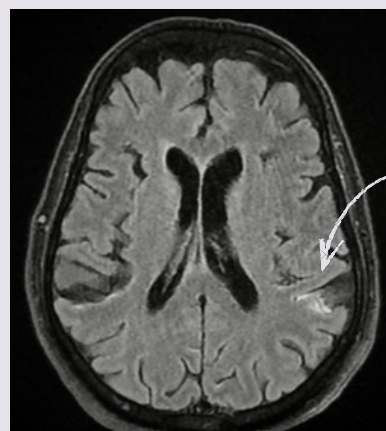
Axial view of brain MRI in FLAIR sequence showing cortico-subcortical hyperintensities in the left parietal region.
